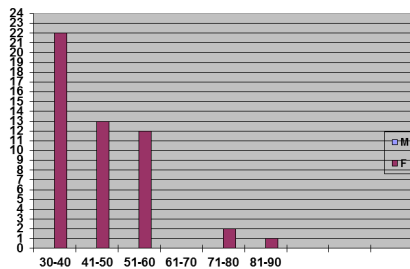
Age and sex distribution of patients who underwent breast MRI.
